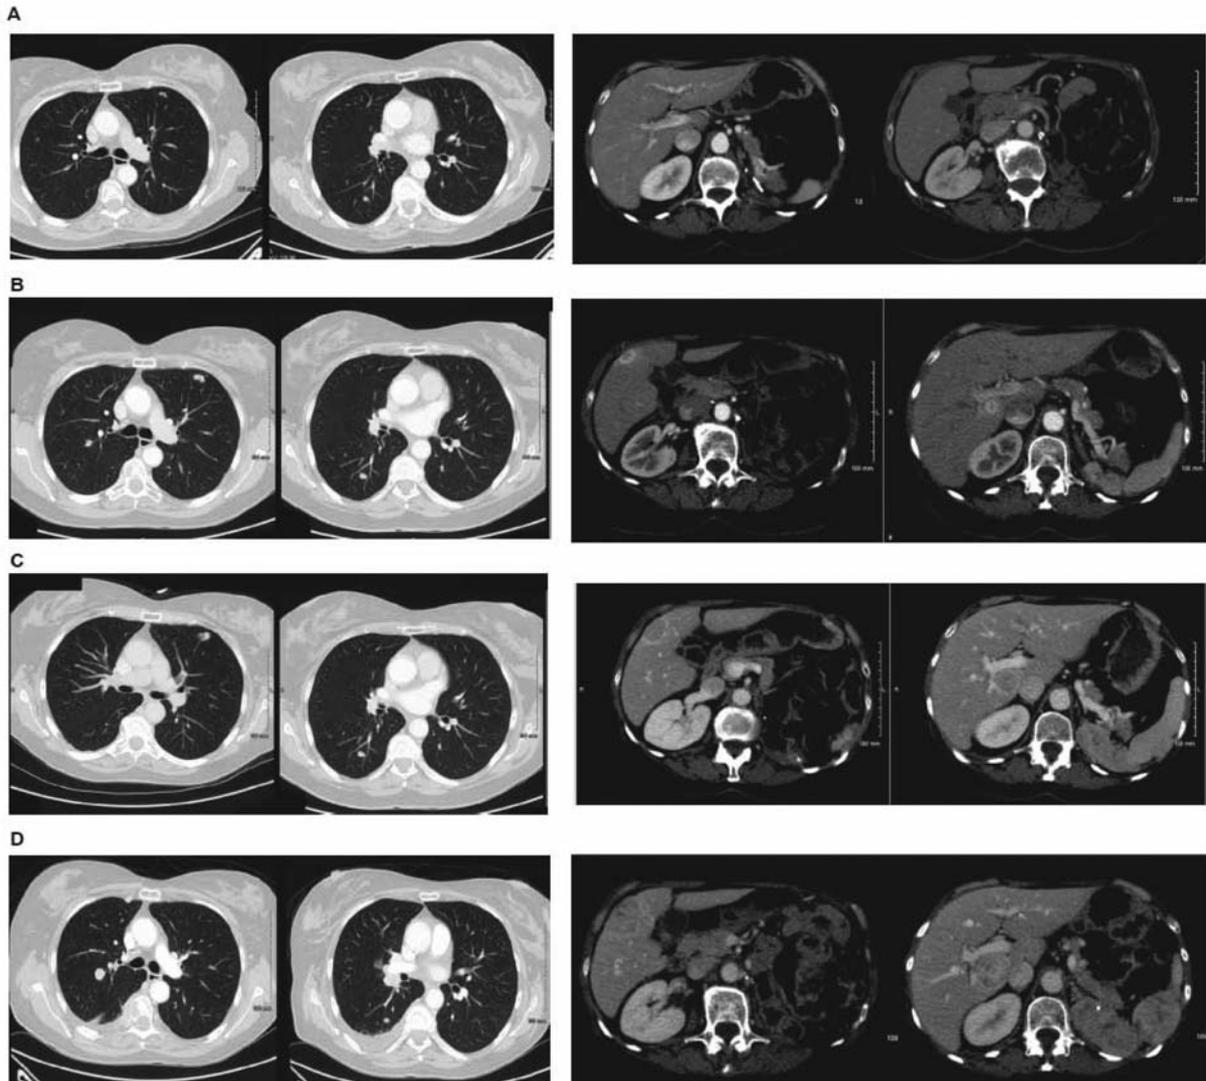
Chest and liver computed tomographic scans at the time of initiation of sunitinib (A); after 12 months, at the time of progression under sunitinib (B); after 18 months, at the time of progression under axitinib (C); after 24 months, at the time of progression under sorafenib (D).
